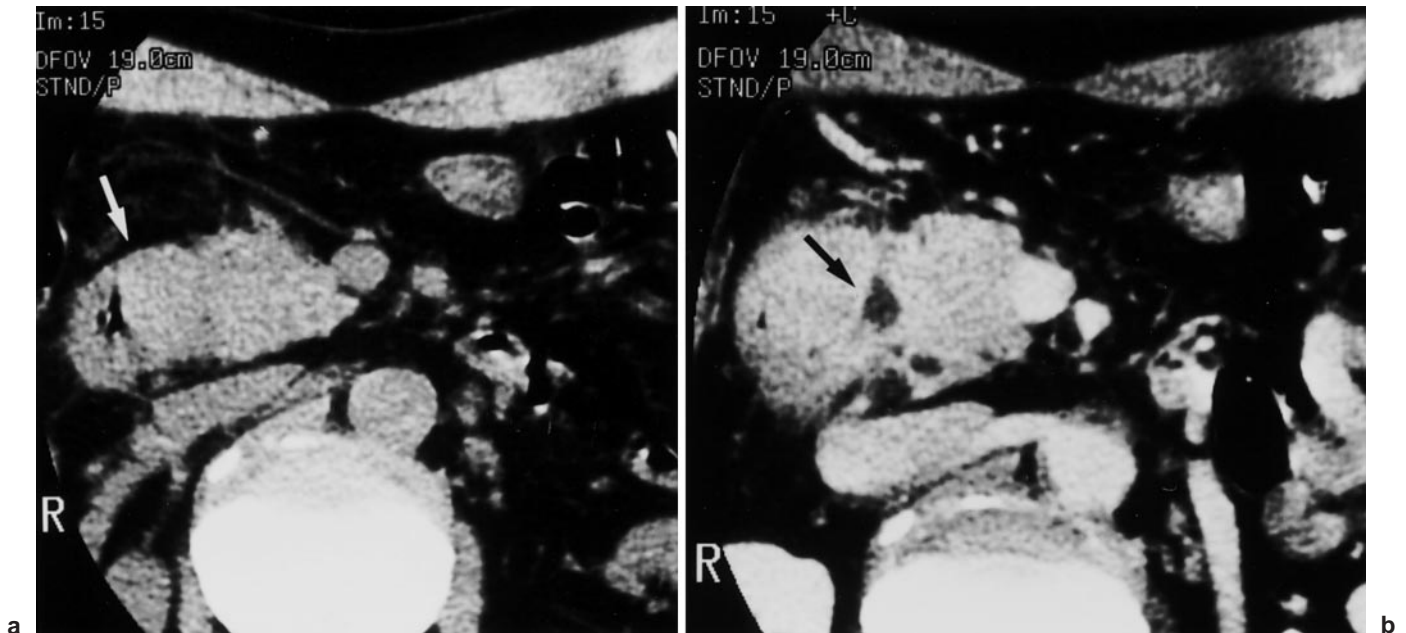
a Abdominal computed tomography (CT) scan showing thickening (*arrow*) of the duodenal wall. b On high-dose enhanced CT scan, the head of the pancreas shows
